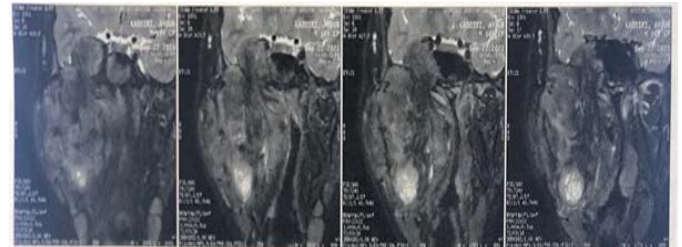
MRI on coronal section showing the tumor infiltrating the ascending branch of the mandible, with bone lysis.
